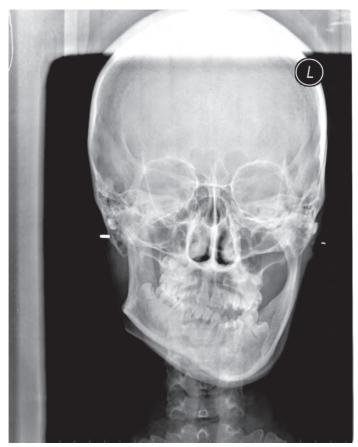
Radiograph of the posterior-anterior projection showing facial asymmetry with fullness of the affected side.
